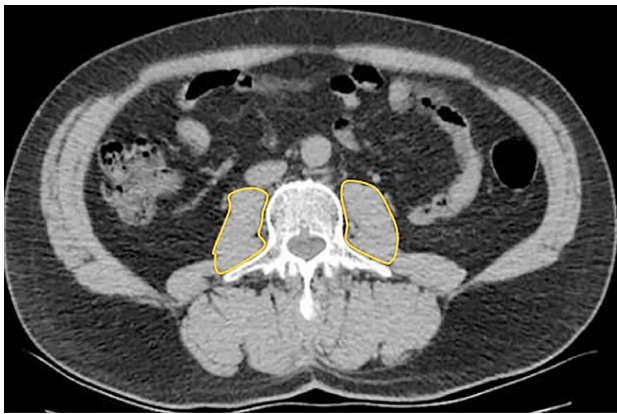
Psoas muscle index evaluation on lumbar computed tomography. The outer edge of the major psoas muscle was traced manually to assess the psoas cross-sectional area at the lumbar third vertebral level with the free hand region of interest. The sum of the left and right psoas cross-sectional area (cm^2) was divided by the square of the individual's height (m^2)
